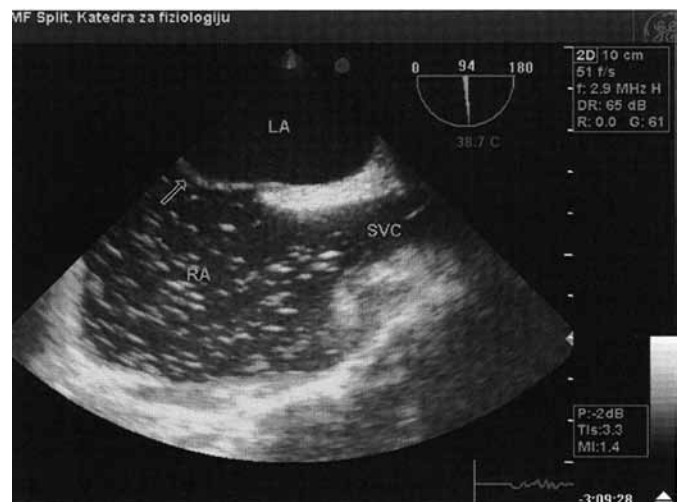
Transesophageal echocardiographic view of the heart using a contrast agent. Figure reveals intraatrial septum (arrow) without visible defects and presence of contrast agent solely in the right atrium (RA) during the Valsalva maneuver. LA left atrium; SVC superior vena cava.
